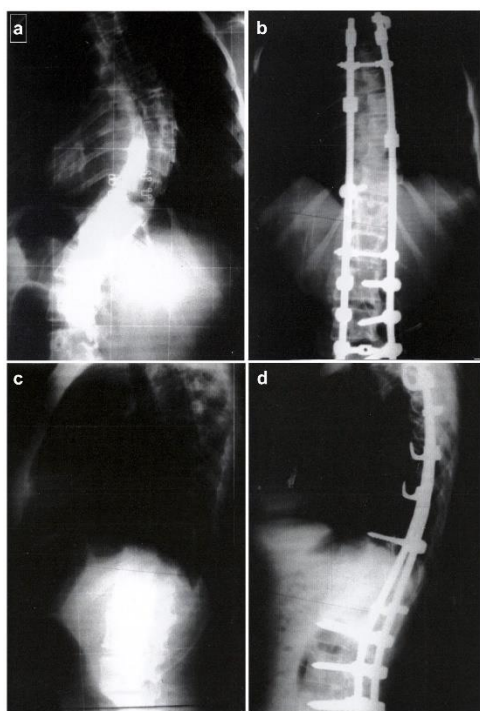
On the frontal plane radiograph of a patient with adolescent idiopathic scoliosis before CD instrumentation (a), the Cobb angles at thoracic and lumbar regions were 64° and 50°, which decreased to 23° and 16° after CD instrumentation (b), respectively. On the sagittal plane radiograph of the same patient before CD instrumentation (c), thoracic kyphosis, lumbar lordosis, and thoracolumbar junction angles were 26°, -40°, and 0°, which changed to 12°, -7°, and -7° (d), respectively.
